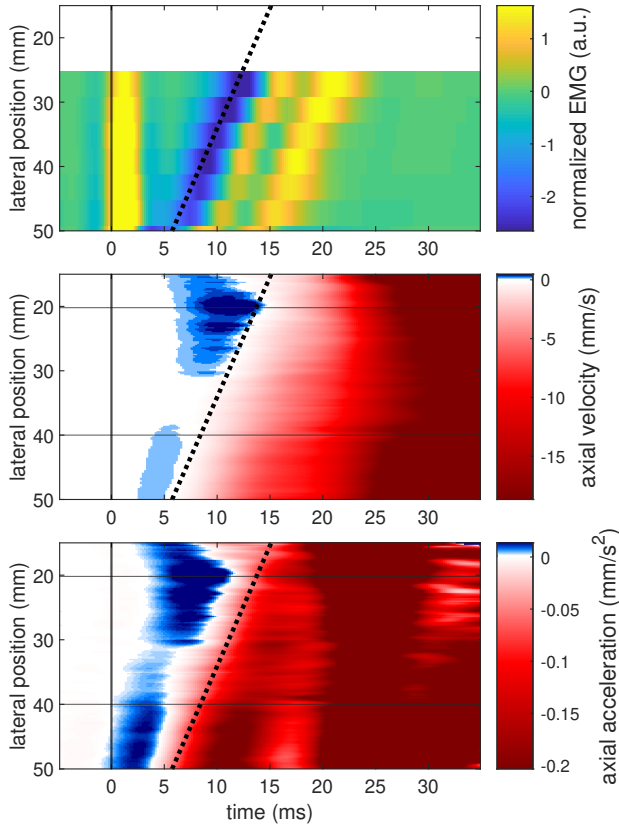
Typical result for participant 1, M-mode at depth 10 mm. (Top) EMG of column beneath ultrasound probe. Velocity of the action potential $V_{ap} = 3.73 \text{ m s}^{-1}$. The black dotted line denotes the depolarizing peak in the EMG signal in every panel. The yellow peak at $t = 0 \text{ ms}$ is a stimulation artifact. (Center) axial tissue velocity along the M-mode. (Bottom) axial tissue acceleration. It can be seen that the blue area in the tissue velocity and tissue acceleration precedes the depolarizing peak in EMG, and has a slope very similar to the black dotted line fitted through the depolarizing peak. The velocities arrival times for participant 1 listed in Table 2 were in some trials fitted on the first blue wave, and in some trials on a red wave. In this trial, this would be the wave between 5 and 15 ms, but this wave could not be found with the Radon tracking method since it is not as outstanding as the blue wave.
